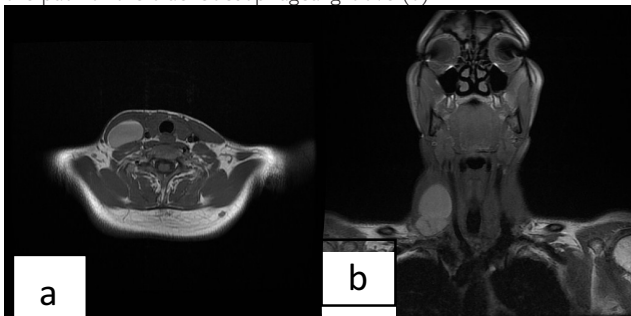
Branchial cleft cyst on T1-weighted axial scan (a) and without postcontrast enhancement on coronal scan (b).
